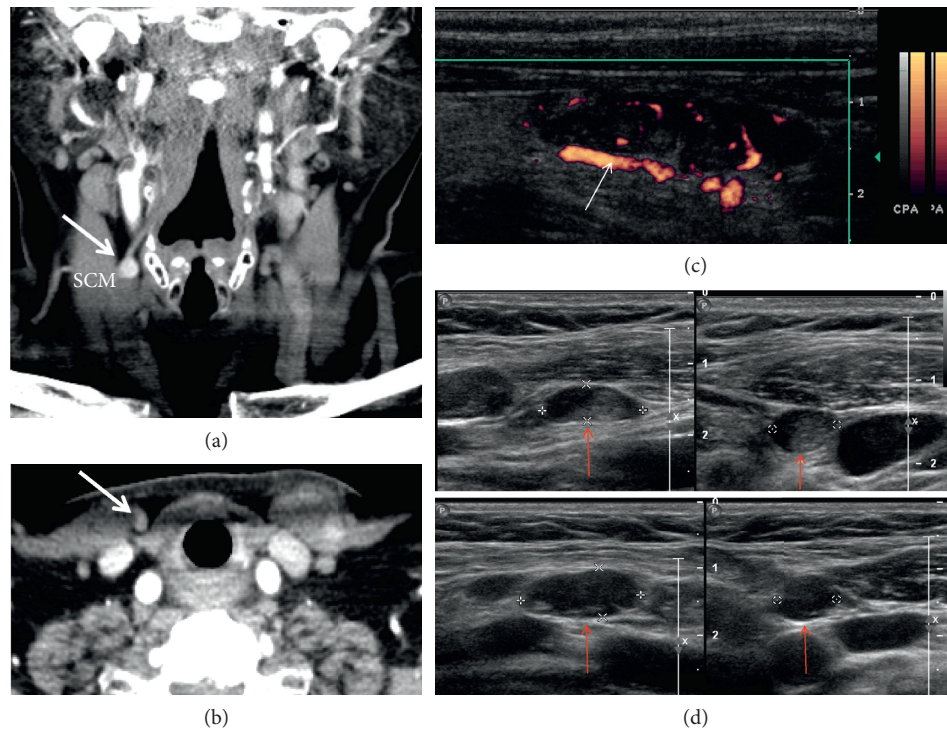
Autotransplanted parathyroid gland and parathyromatosis. A 70-year-old female presents with hyperparathyroidism after remote thyroidectomy. Coronal (a) and axial (b) four-dimensional computed tomography (4DCT) shows a hyperenhancing parathyroid gland (thick arrows) superficial to the right sternocleidomastoid muscle (SCM). Power Doppler ultrasound (c) of the autotransplanted hypoechoic nodule shows a polar feeding vessel (thin arrow) and peripheral rim of vascularity. Additional well-circumscribed mostly hypoechoic nodules consistent with multiple implants of parathyroid tissue (d) (red arrows) are also visualized.
